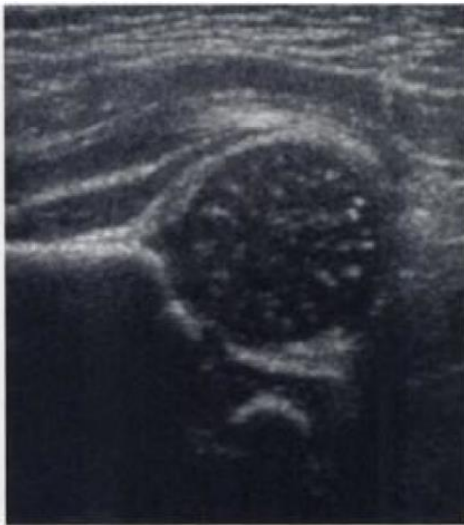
Standard coronal ultrasound of the normal infant hip joint. The promontory is sharply defined and the bony acetabular roof is steep. The ossification centre for the femoral head has not yet developed
